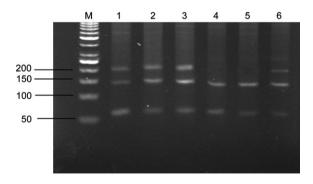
PCR-RFLP analysis of *TIM-3-1541 C>T polymorphism*. Lane M: 50 bp DNA lader; Lanes 1, 2, 3 and 6: heterozygous CT genotype; Lanes 4 and 5: homozygous CC genotype.
